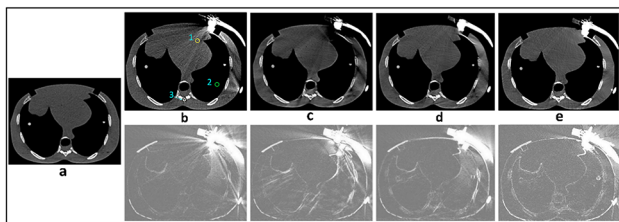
a (CT_{ref}), b (CT_{art}) and artifact corrected CT scans by c (iMAR), d (MDT) and e (CCS-MAR). The absolute differences of b, c, d, and e with the a is given below them. The positions of region of interest (1: heart, 2: lung, 3: bone) for the Hounsfield unit measurements are shown in CT_{art} .
